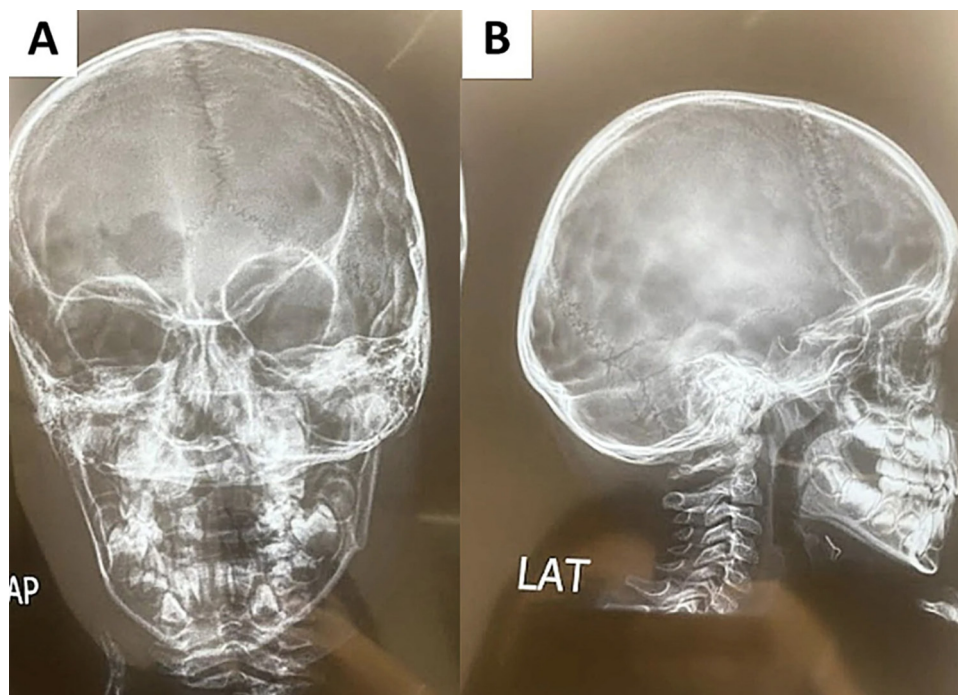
Skull radiography shows an area of bone rarefaction with irregular margins involving the right frontal bone. A: The image shows the anteroposterior view; B: It shows the lateral view.
